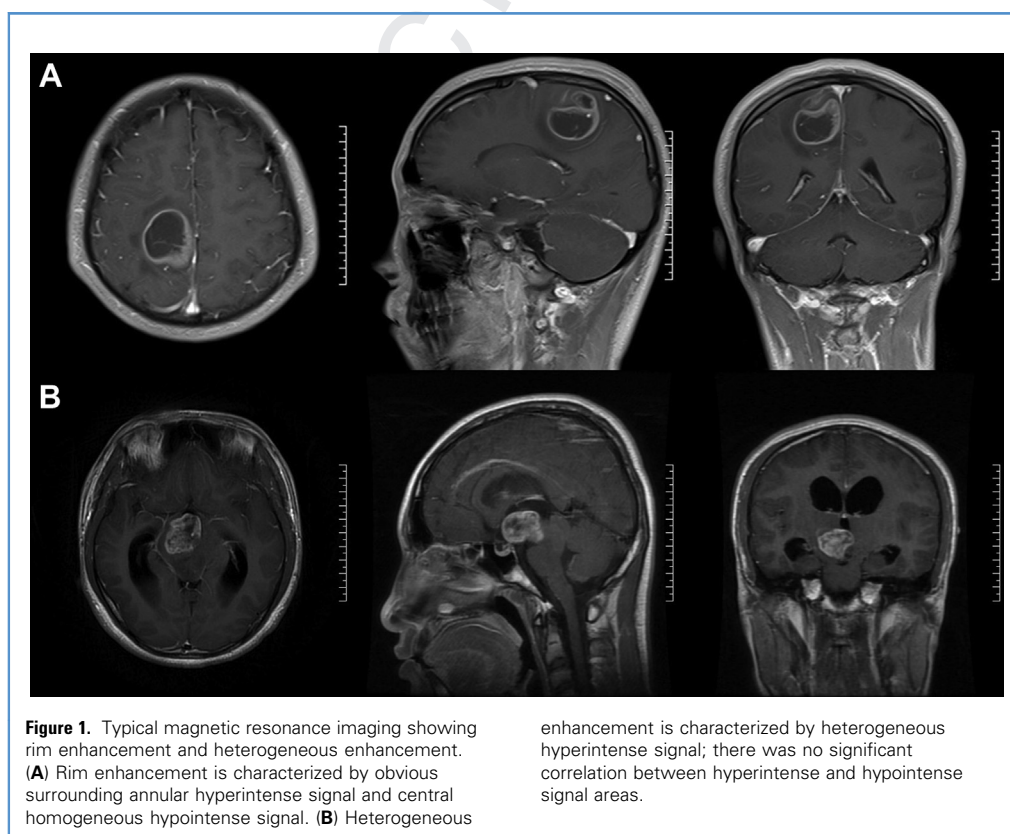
Typical magnetic resonance imaging showing rim enhancement and heterogeneous enhancement. (A) Rim enhancement is characterized by obvious surrounding annular hyperintense signal and central homogeneous hypointense signal. (B) Heterogeneous
